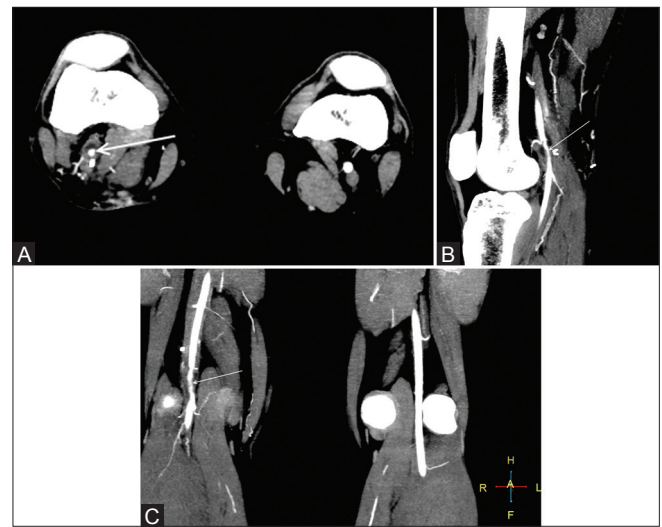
(A-C): (A) Axial, (B) Sagittal and (C) Coronal CT angiography images show mild residual cystic disease with reduction in popliteal artery stenosis (white arrow)
